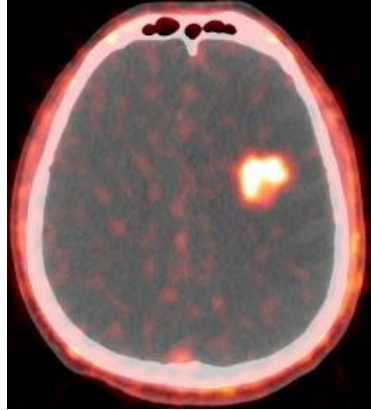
Representative PET/CT F-18 ML-10 image of a male patient, 48 years old, diagnosed with kidney cancer brain metastases, pre-CK.
